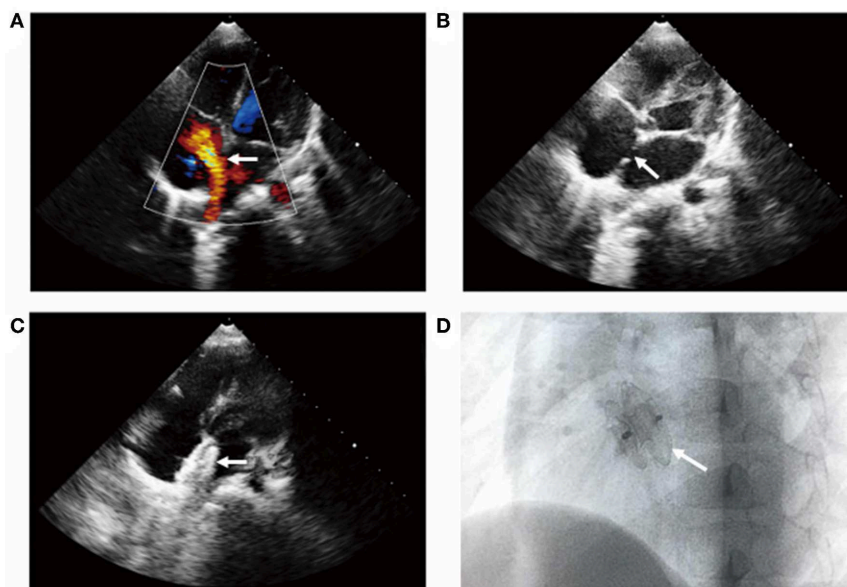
Transcatheter closure of ASD shown by transthoracic color Doppler echocardiography. The apical four-chamber section showed (A) left to right shunt at the level of atrial septum, (B) the continuous interruption of the atrial septum with a loss of about 14 mm, and (C) the atrial septal occluder was well-positioned without residual shunt (see arrow). (D) X-ray examination of left anterior oblique position after interventional closure showed that the occluder was fixed and the shape was normal (see arrow).
